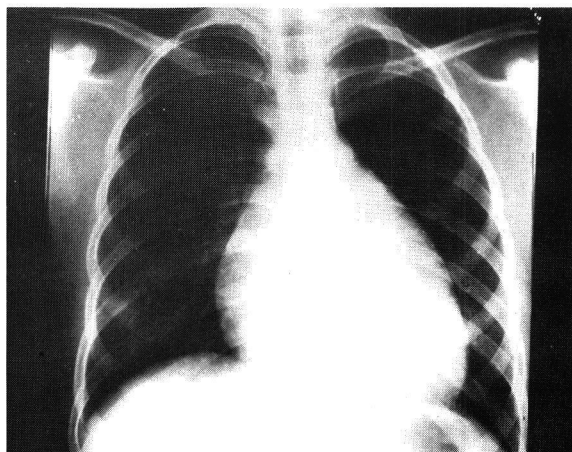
Plain chest x-ray showing cardiomegaly with pulmonary oligemia.
